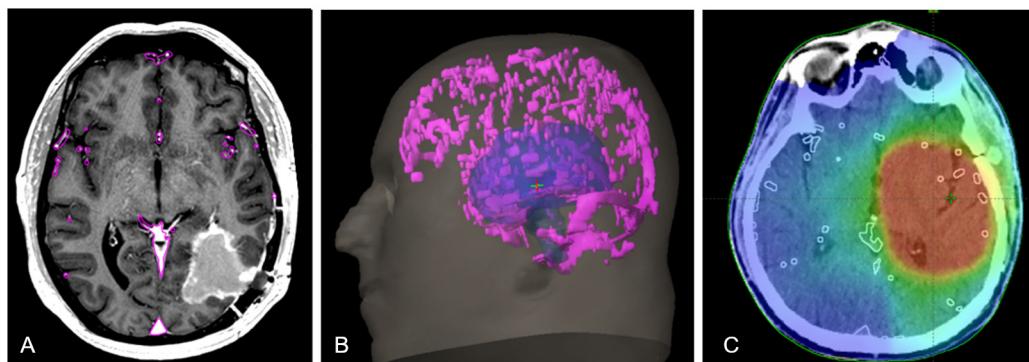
A) Manual segmentation of vessels in T1-weighted axial MR scans in the RT treatment planning system. B) Vessels and PTV shown in a 3D image. C) Dose color wash of the final radiotherapeutic plan with delineated vessels.
